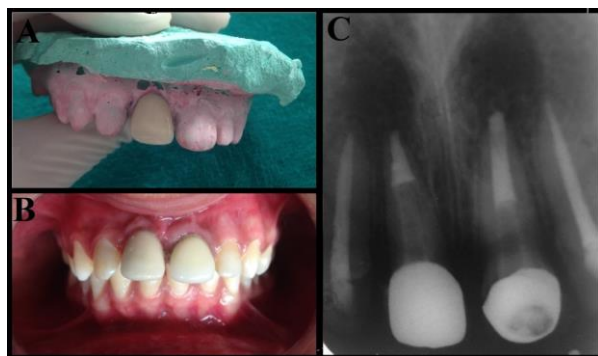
Figure 4: A. PFM crown fabricated wrt 11. B. Clinical photograph after crown luting wrt 11. C. post operative radiograph.
